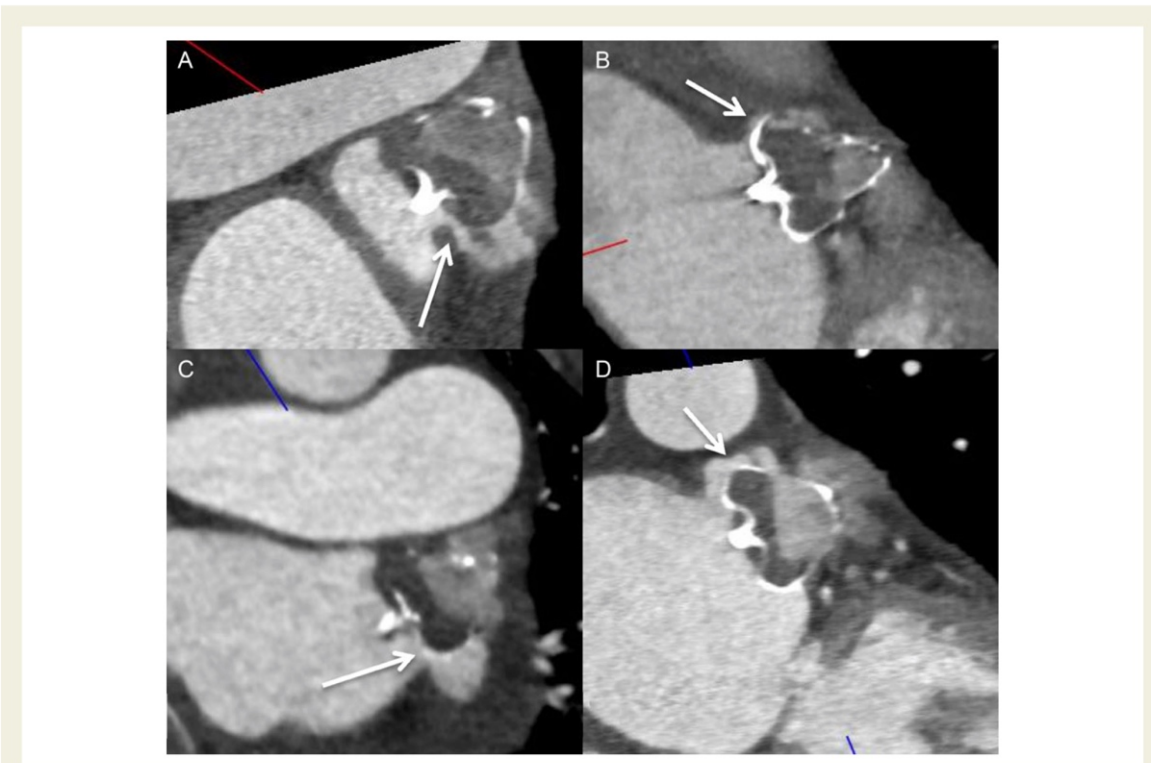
Contrast-enhanced CT images of four different examples of WATCHMAN implanted devices with ostial peri-device gaps with residual contrast patencies of the LAA.
